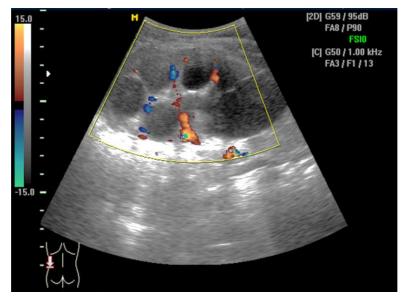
Hydronephrotic transformation of the left kidney. Severe dilatation of pelvis and calyces. Doppler: reduced renal blood flow
